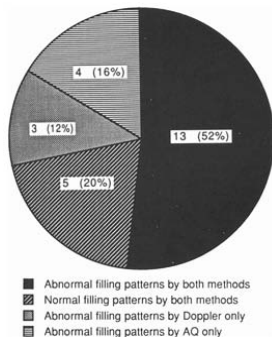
Relative distribution of findings by acoustic quantification (AQ) and Doppler echocardiography in 25 patients with left ventricular hypertrophy and reliable Doppler studies.
